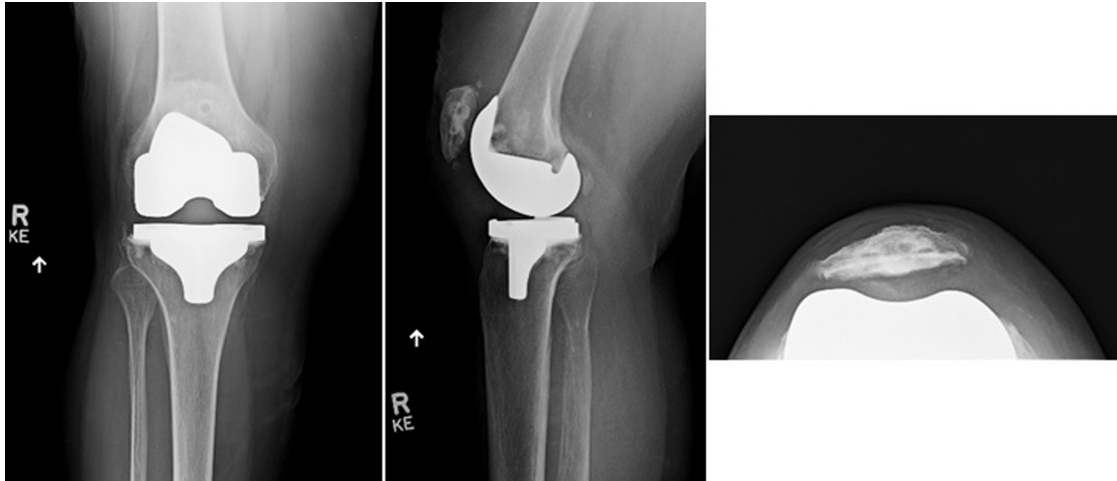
Radiographs of the patient showing stable alignment at her most recent clinic visit after the operation for the joint infection.
